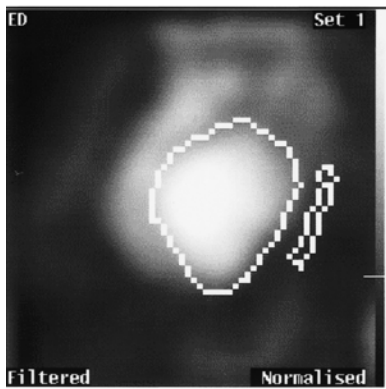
Measurement of left ventricular function by echocardiography (a,b), radionuclide ventriculography (c,d,e), and cardiovascular magnetic resonance (f, g, h, i) in the same patient. (a) Apical four chamber view in diastole, and (b) systole with endocardial border and analysis by method of discs. (c) Radionuclide ventriculography diastolic and (d) systolic images with computerized analysis of ejection fraction (e). Vertical long axis (f) and horizontal axis (g) diastolic frames by cardiovascular magnetic resonance. A stack of short axis images (h) are acquired from the horizontal long axis view. (i) This represents the diastolic frame of one 16 frame short axis cine. The ejection fraction in this patient by 2D echo was 31%, radionuclide ventriculography was 18%, and cardiovascular magnetic resonance was 25%
